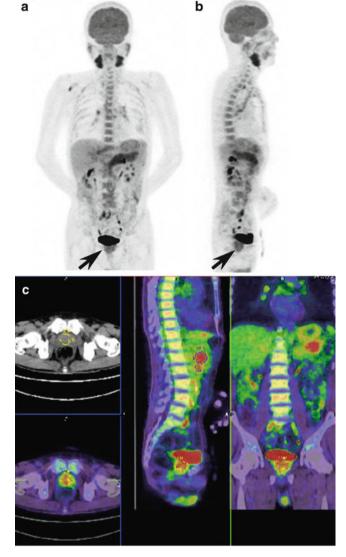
¹⁸FDG-PET images of a case with IgG4-related prostate lesions as a part of systemic IgG4-RD ((a) frontal view, (b) lateral view, (c) color images). In the lesion-bearing prostate gland, marked ¹⁸FDG accumulation is found (*right arrow*), in addition to which accumulation was also noted in the bilateral submandibular glands, parotid glands, pancreas, right axilla, and pulmonary hilum lymph nodes
